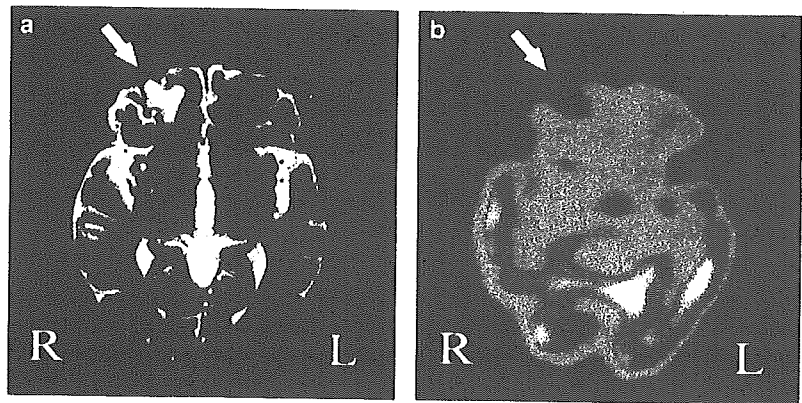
(a) Magnetic resonance imaging scan showing a small contusion and cerebral atrophy in the right orbitofrontal region. (b) Single-photon emission computed tomography revealing hypoperfusion in blood flow in the same region as in (a).
